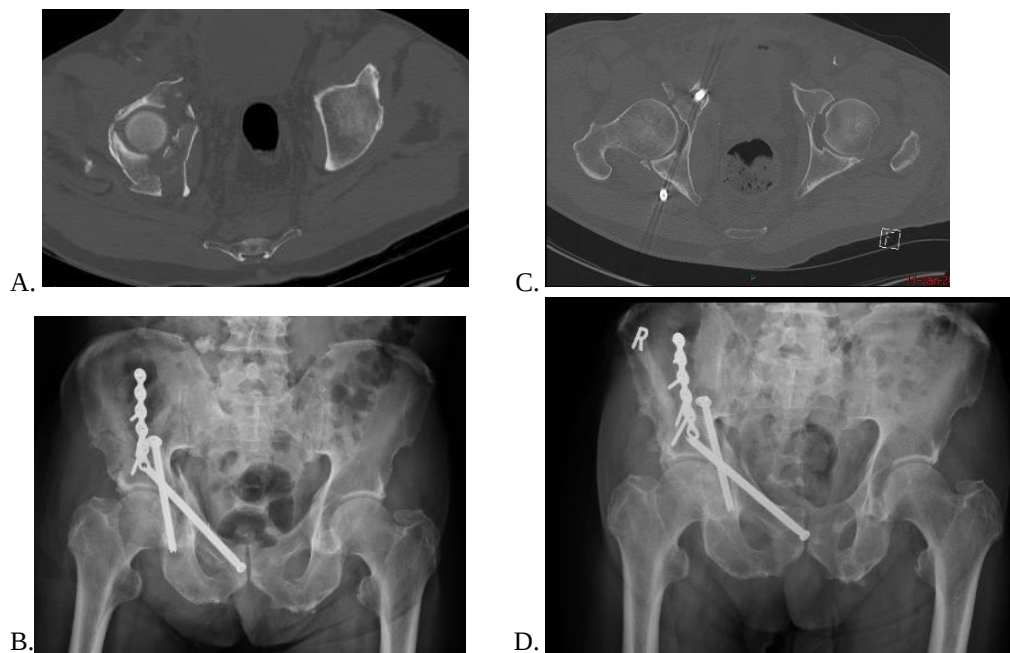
(Patient who developed foot drop). A – Preop Axial CT scan slice showing the fracture B – Post-operative radiograph. C – Post-op CT scan axial slice highlighting screw position. D – Post surgical revision for screw placement radiograph with recovery of foot drop.
